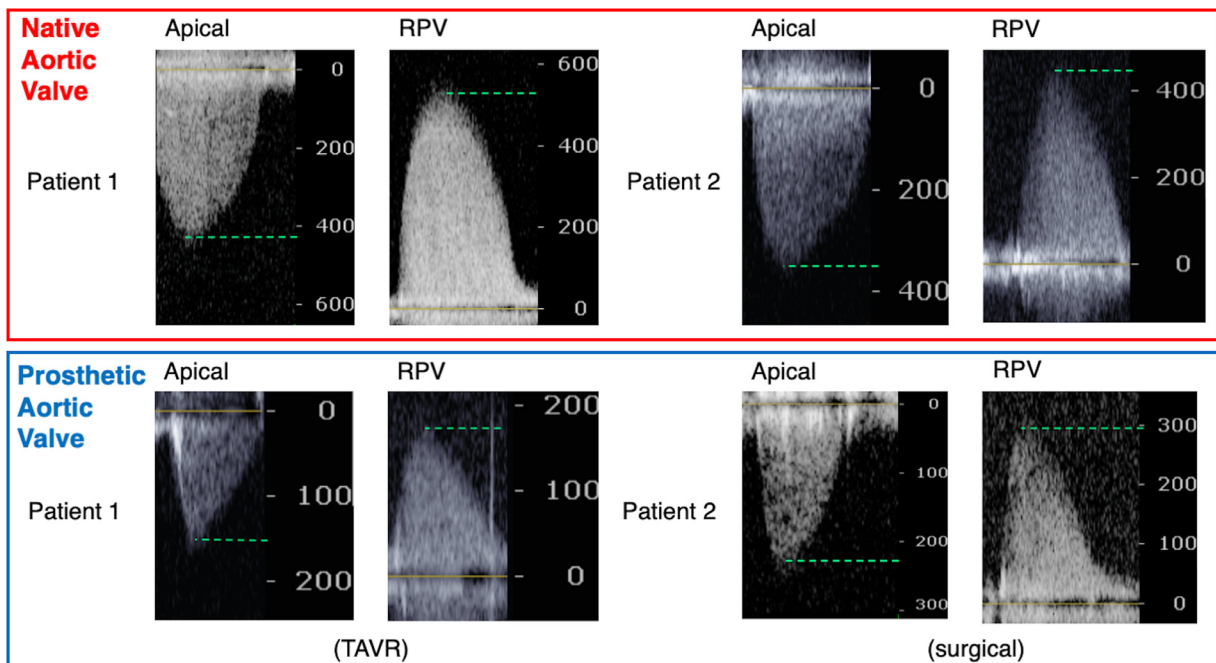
Paradigmatic examples of hemodynamic assessment in apical versus right parasternal view in native aortic valve stenosis (red box) and after surgical or percutaneous aortic valve replacement (blue box). Green dashes indicate the reached peak velocity (in cm/sec).
